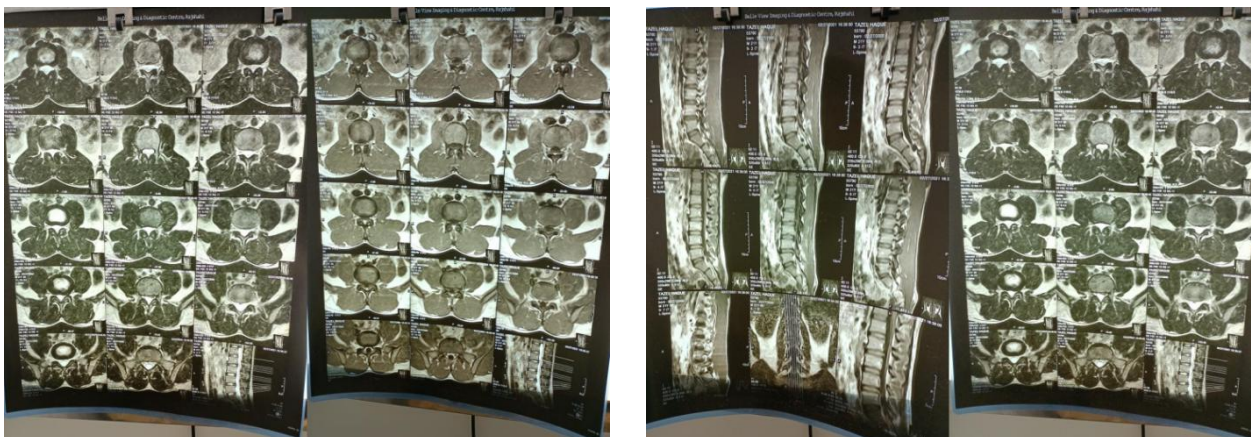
Figure A, B & C: MRI of Lumbar spine showing the prolapsed lumbarintervertebraldisc identification.
